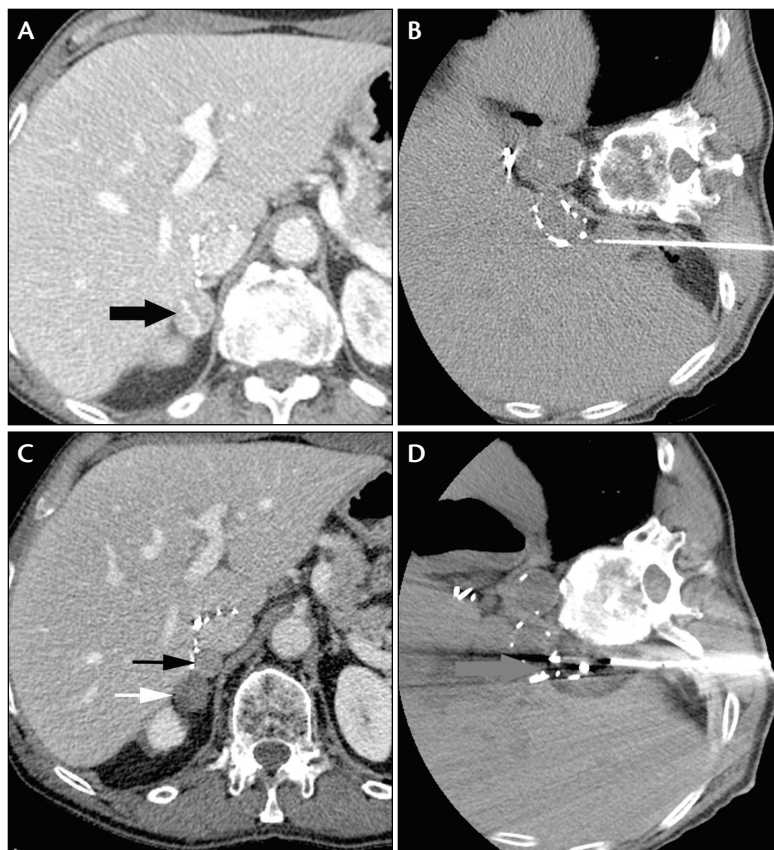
Contrast-enhanced CT axial image demonstrated enhancing right adrenal mass (A, arrow), which was subsequently confirmed as metastatic HCC with percutaneous biopsy. The radiofrequency ablation probe was positioned within the metastasis (B). Contrast-enhanced CT image obtained 10 months after radiofrequency ablation demonstrated a recurrent right adrenal mass (C), which was treated with percutaneous cryoablation (D).
